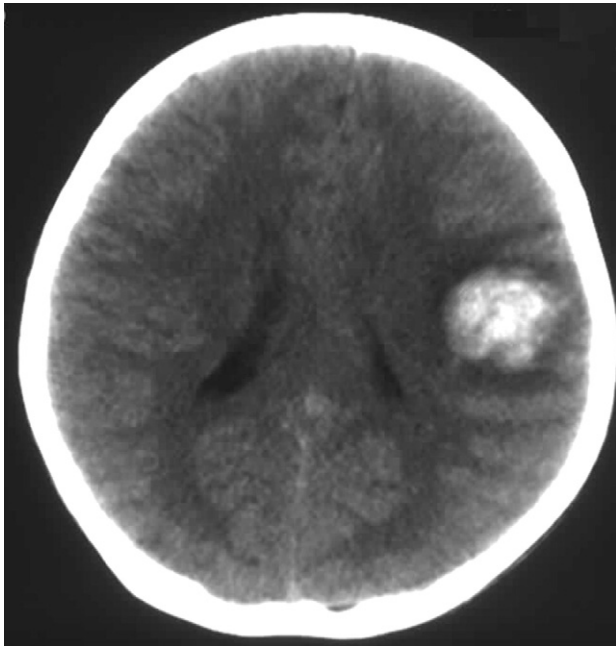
Axial computed tomography scan reveals an acute cerebral hemorrhage in the parietal lobe.
